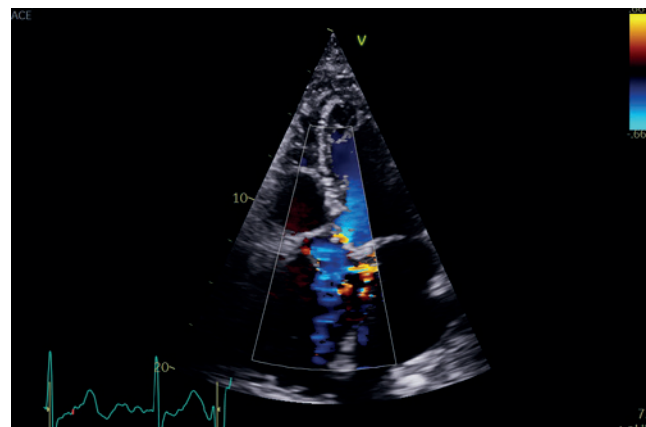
Apical five-chamber view with colour flow Doppler filling approximately 30% of the ascending aorta
